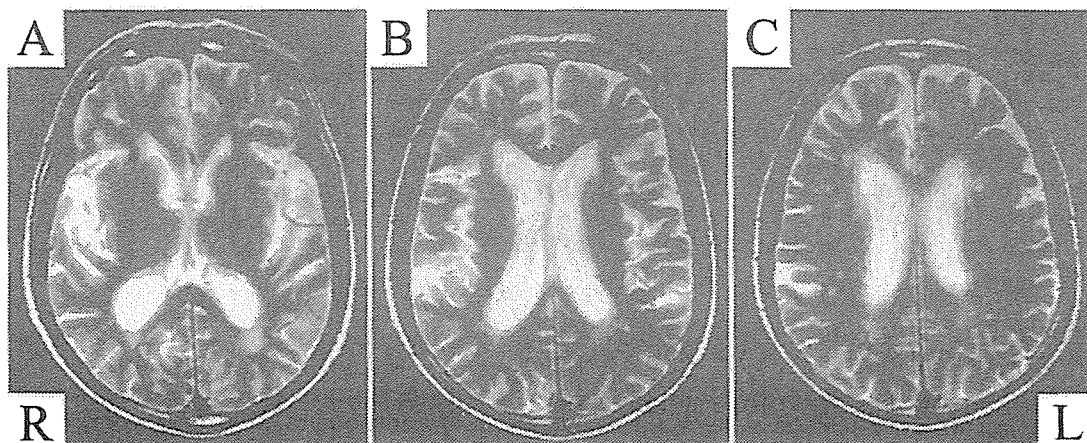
Case 1. Axial T<sub>2</sub>-weighted MR images obtained at admission, showing small areas of high signal intensity in the bilateral corona radiata. L = left; R = right.
